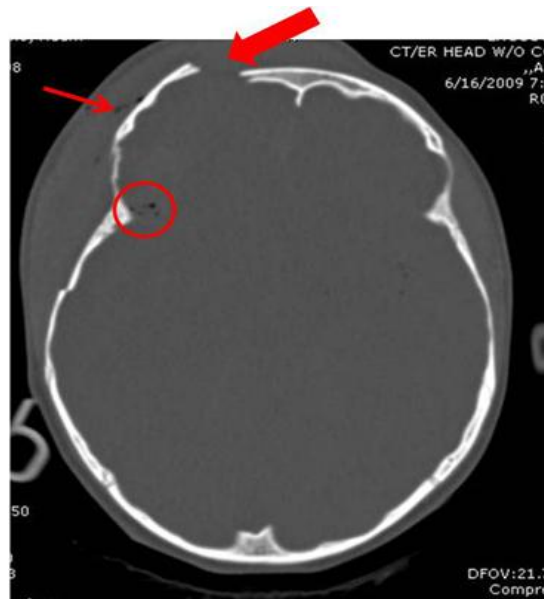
CT Brain Linear Skull Fracture, (Robbins, 1987).
